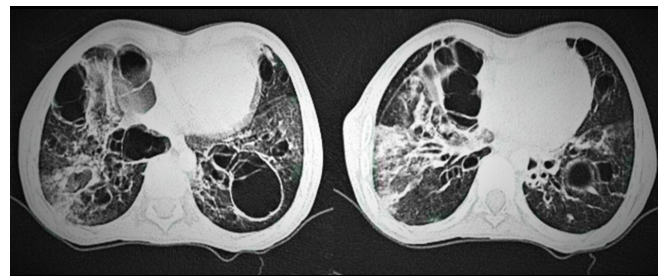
Admission thoracic tomography. On admission to the hospital (10th day of illness), pulmonary CT showed alveolar radiopacities with interstitial and ground glass pattern in both lung fields, diffuse distribution, bilateral cystic radiolucent images of right predominance in relation to COVID-19 pneumopathy.
